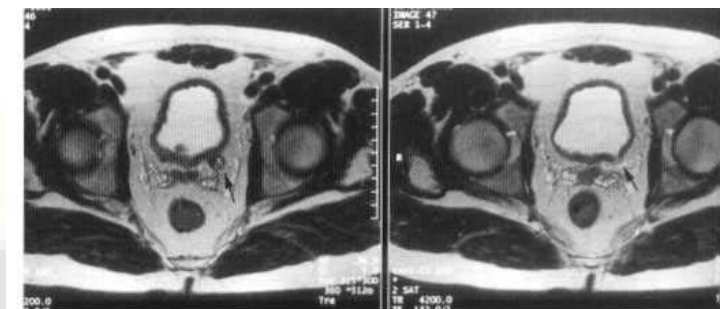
MRI scan (transverse T₂-weighted images) showing a small left paraureteric congenital bladder diverticulum (arrows).
